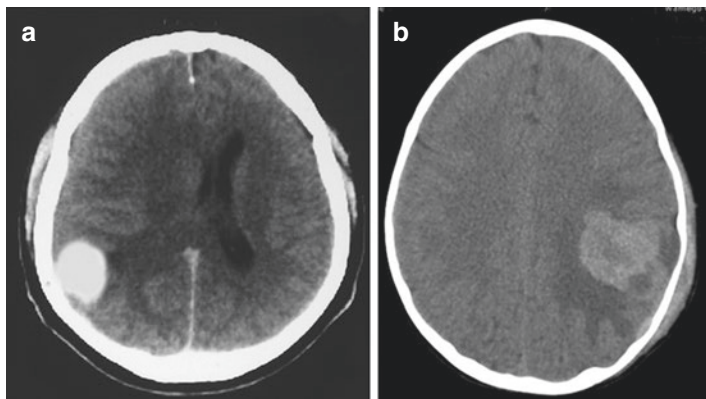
Non-contrast CT scan showing right parietal intracerebral hematoma secondary to an AVM (a). Note the surface location and the swelling in the underlying hemisphere. Compare with the CT scan of the 5-year-old who fell down and was thought to have a contusion of the left parietal lobe (b). The surrounding oedema and the dull greyish heterogenous appearance were significant red flags to suggest that this was not just an acute clot from a fall but more likely to be a tumor
